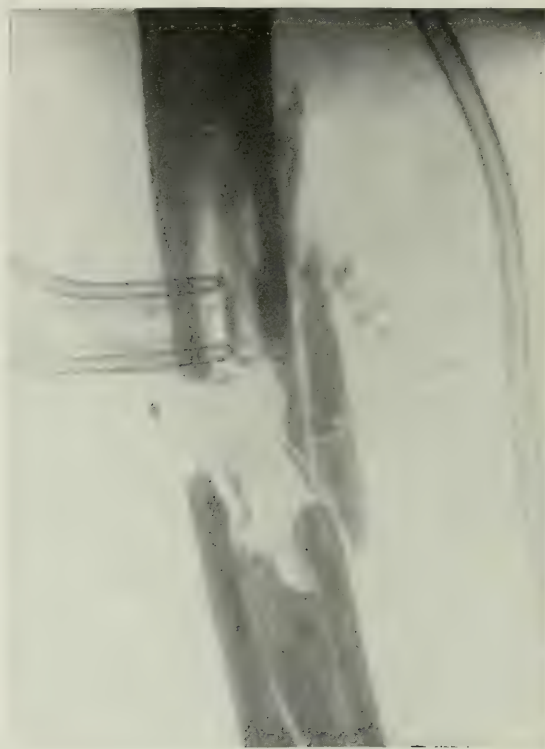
Roentgenogram Case 3, showing fracture of left femur with deep fissures.
